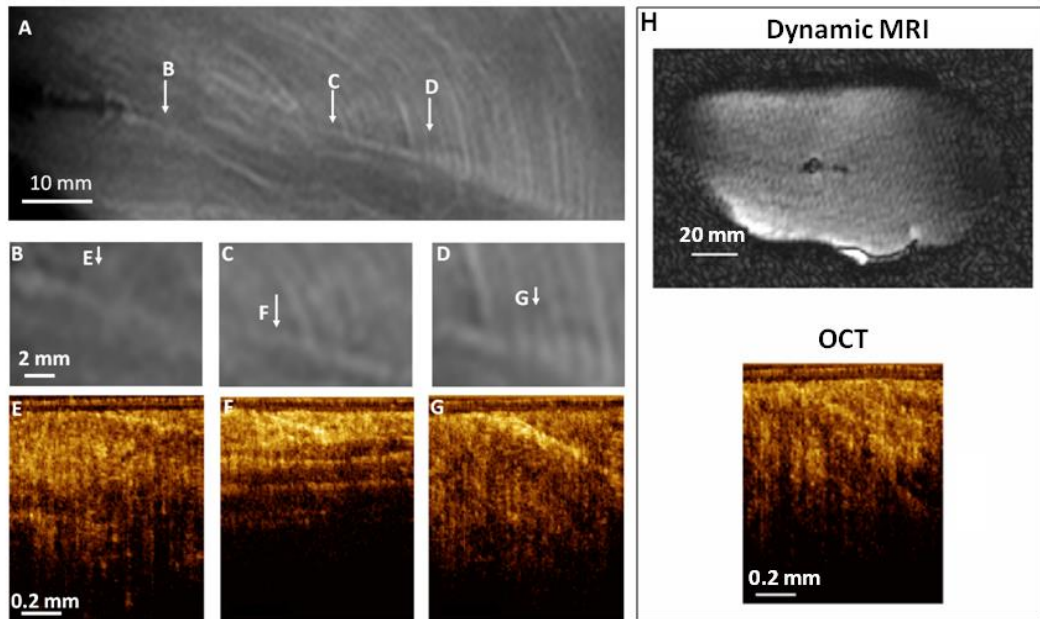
Co-registered MRI/OCT images of chicken breast tissues ex vivo.
